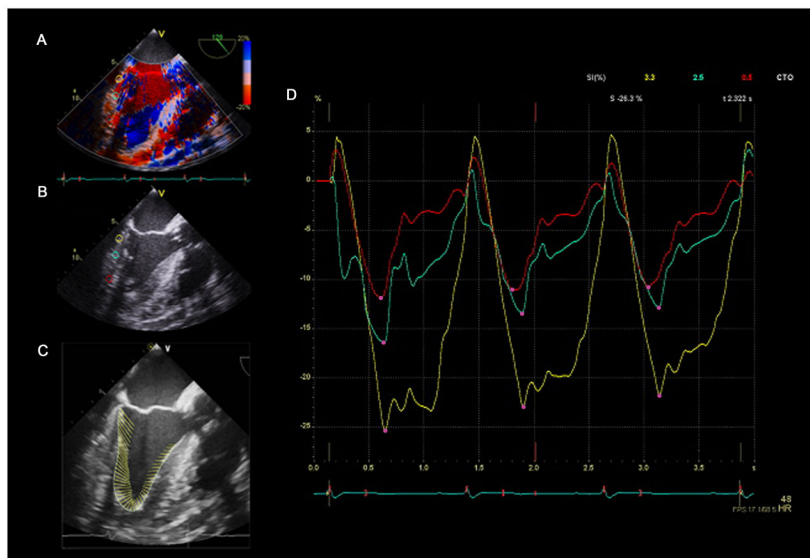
Tissue Doppler imaging (TDI) strain. (A) A mid-esophageal long-axis view with color tissue Doppler. (B) The operator positions three sample volumes (yellow, aqua, and red circles) within the inferolateral wall to measure TDI strain at each point. (C) Demonstration of the myocardial vector of motion using VVI strain analysis software documents suboptimal alignment with the ultrasound beam. (D) Strain curves from the “encircled” region in panel B are shown in the corresponding color. Three cardiac cycles are shown, and peak systolic strain for each region is identified by a pink dot. The “red” sample volume positioned nearest to the apex demonstrates the lowest strain because of poor alignment of the region of interest and vector of motion with the ultrasound beam. “Reprinted with permission, Cleveland Clinic Center for Medical Art & Photography © 2013. All Rights Reserved.”
